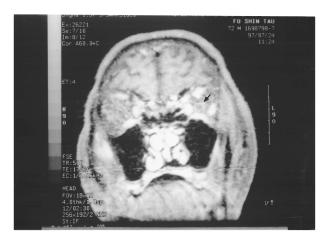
Case 1: Magnetic resonance imaging showed enlarged and well-enhanced left optic nerve sheath (arrow) after contrast injection on T_1 -weighted coronary image.
